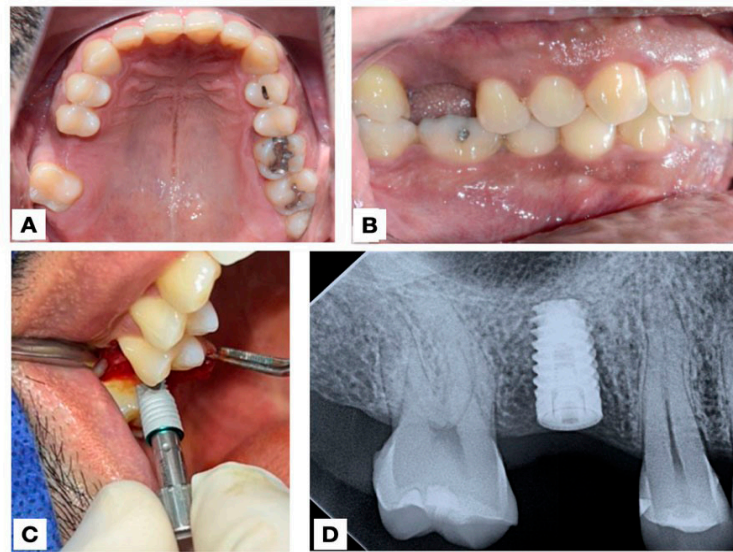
Initial photographs. A. Preoperative maxillary occlusal view. B. Left lateral view (preoperative). C. Implant placement in area of tooth 16. D. Postoperative digital dentoalveolar radiograph.
